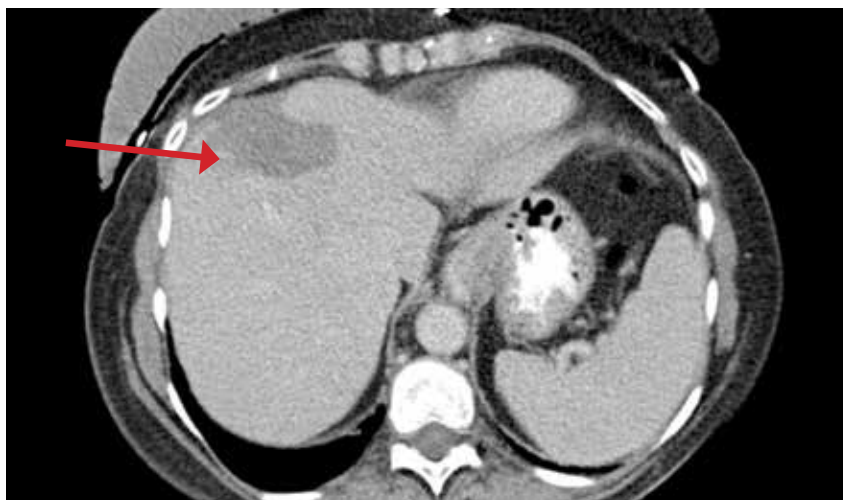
Follow-up CT shows hypo-intensity in the entire ablation zone (red arrow) correlating well with the zone of hypo-perfusion delineated by the  $^{13}\text{N-NH}_3$  perfusion PET, but with some involution. No tumor recurrence in the tumor bed or elsewhere in the liver is visible.
